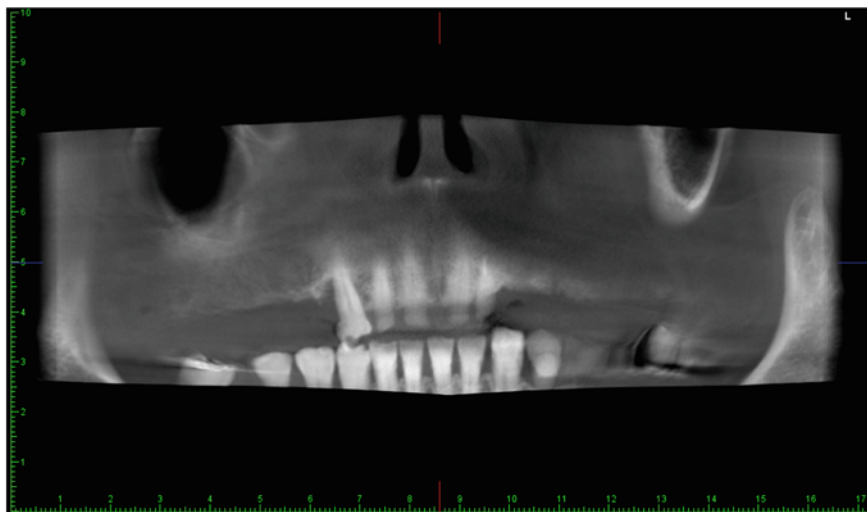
Preoperative panorex CBCT
